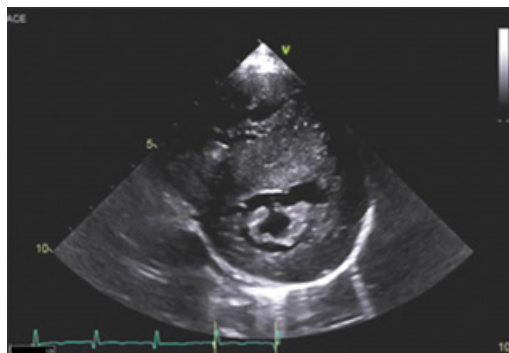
Transthoracic short axis view showing circumferential LV hypertrophy, especially in the septum, and resulting cavitary obliteration. Courtesy of Adam C. Adler, MD.
